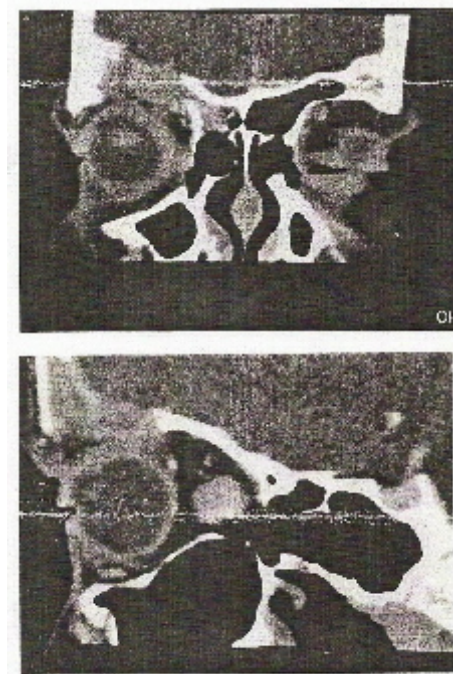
CT of the orbits depicting further bony destruction of right superior orbit with reduction of soft tissue tumor component.
